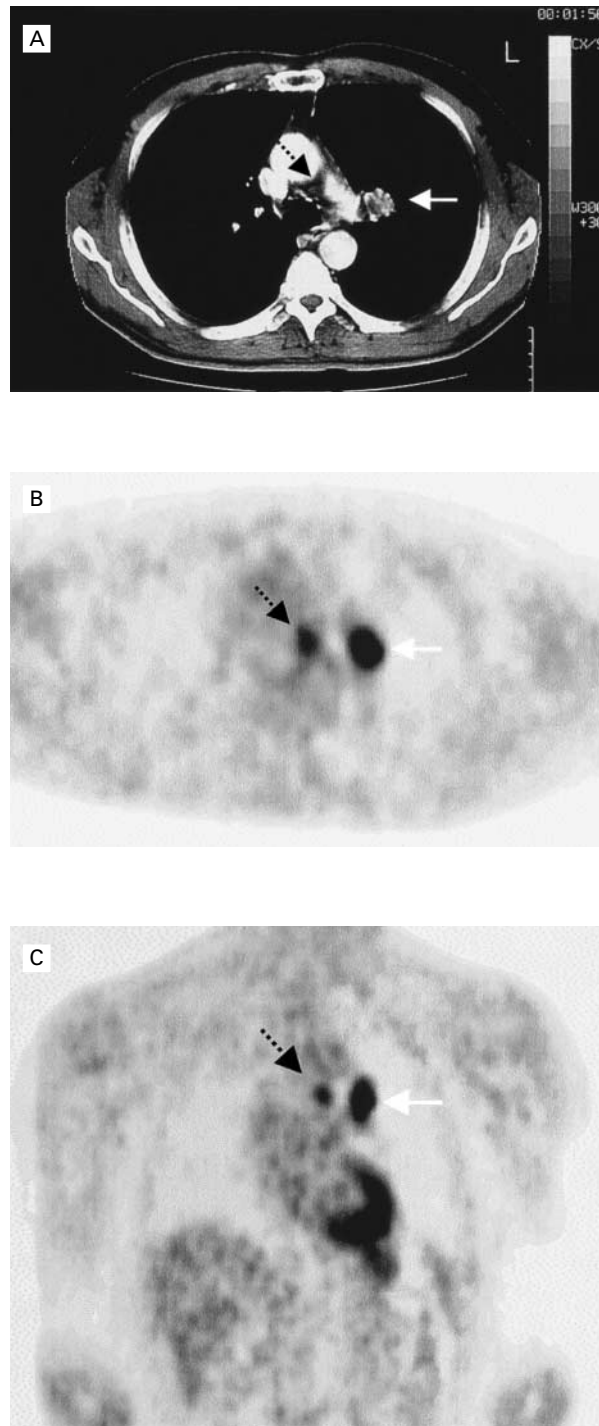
CT and PET Findings in a Centrally Located Adenocarcinoma of the Left Lung and a Small Pretracheal Lymph Node in a Patient with Non-Small-Cell Lung Cancer.
